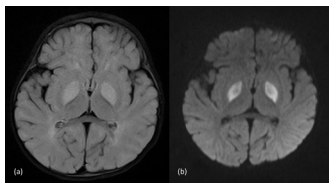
MRI of the brain (A) T2 coronal, and (B) diffusion-weighted sequences showing symmetric hyperintensity and diffusion restriction in bilateral globus pallidus.
